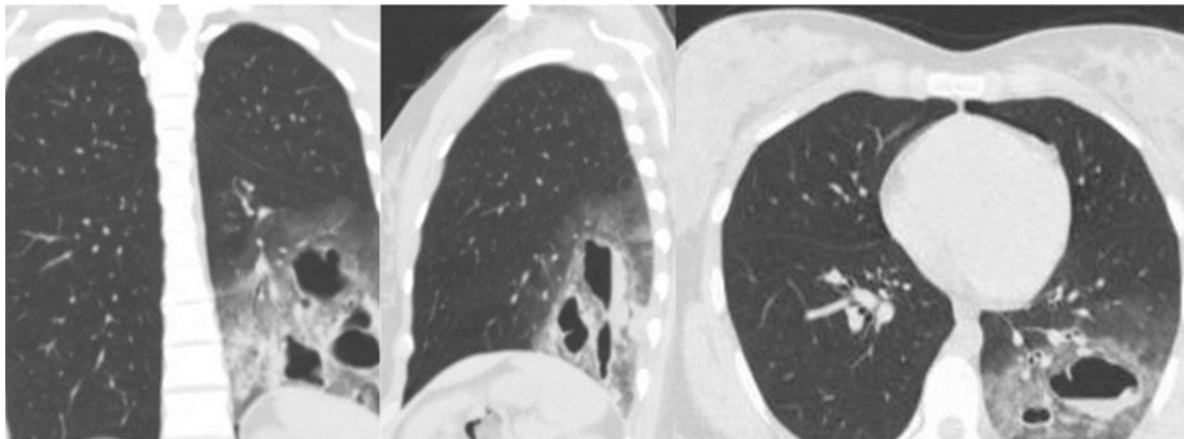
Chest CT showing multiple smooth-walled cavities with air-fluid level in the lateral/posterior area of the left lower lobe surrounded by ground glass.
